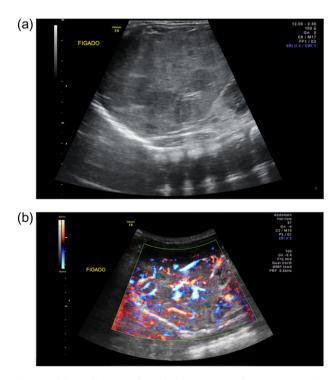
Abdominal ultrasound revealing heterogeneous hepatic structure due to countless hypoechoic nodules (a) with diffuse hypervascularization areas in Doppler ultrasound (b)
